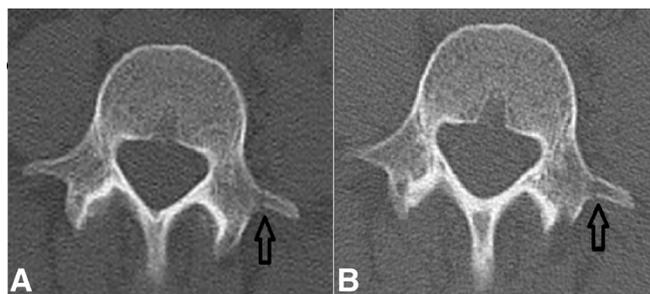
Transverse process fracture missed on body CT. Images from the body CT (A) and lumbar spine CT (B) at the level of the L4 vertebra. A fracture through the left transverse process (arrow) was identified only on the spine CT, but, in retrospect, is visible on both studies.
